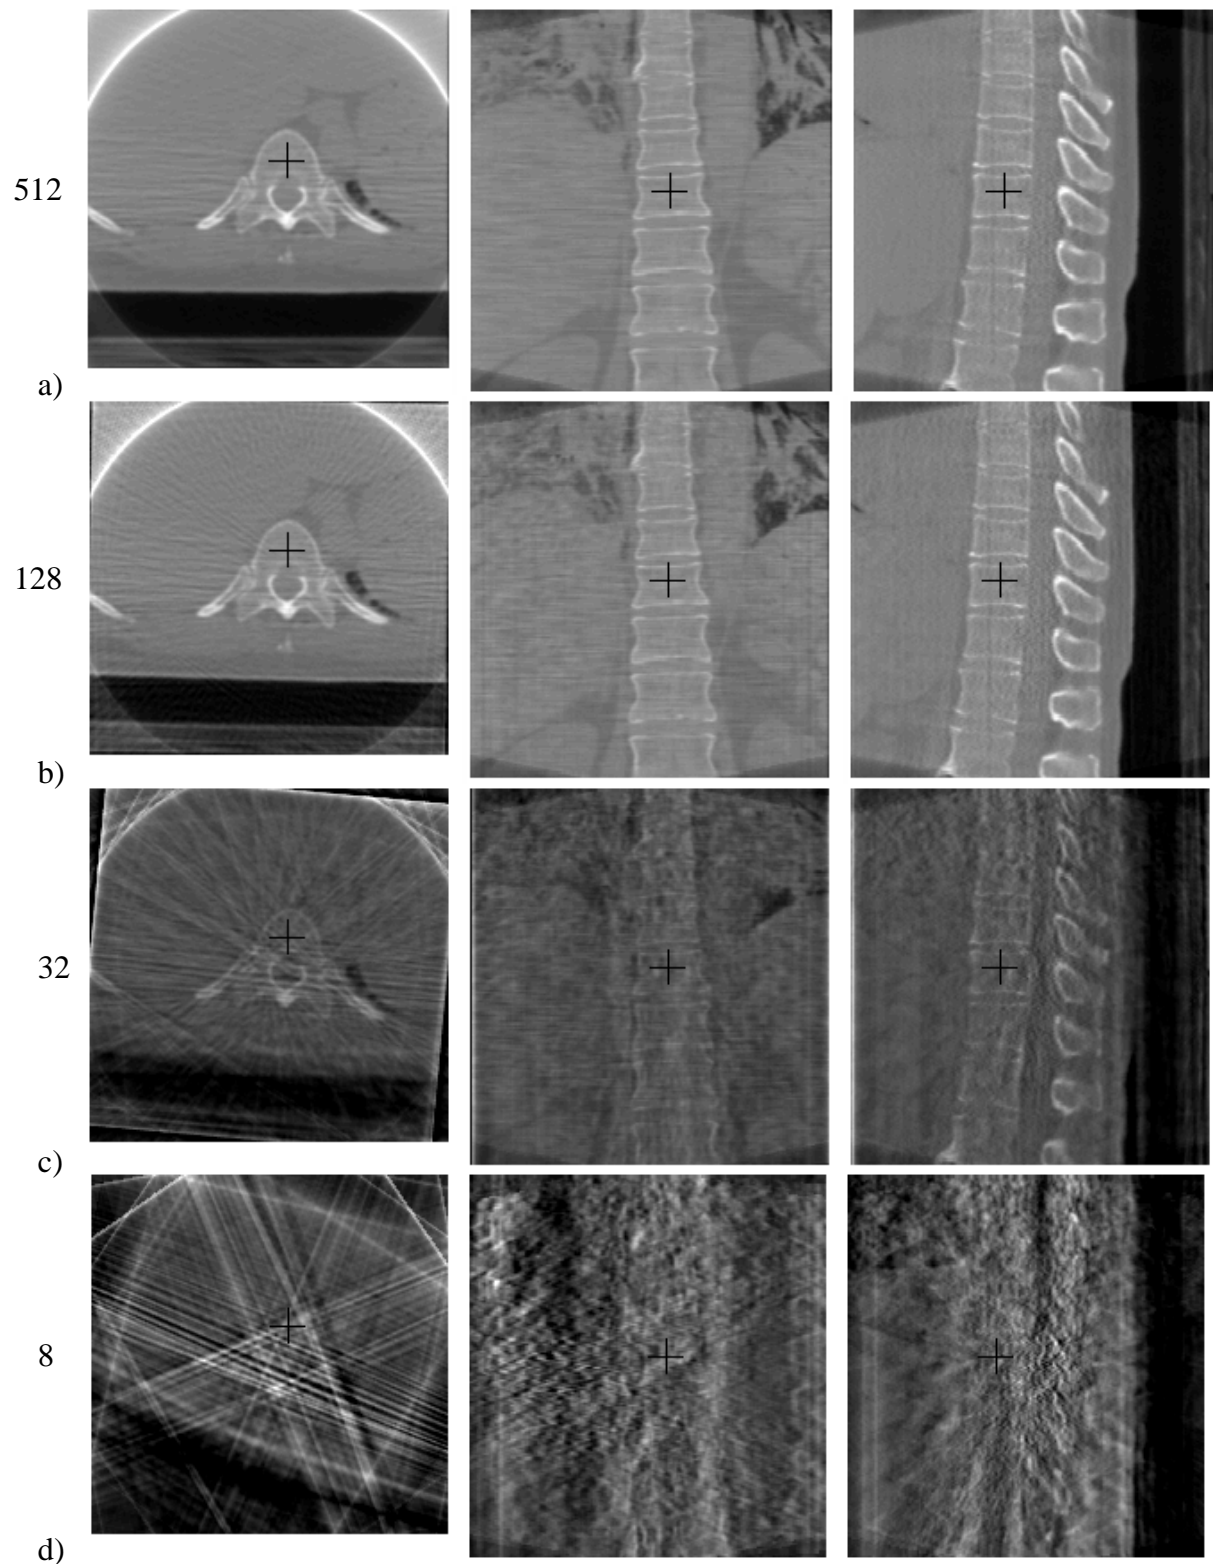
Spine images reconstructed with Feldkamp algorithm using different number of projections. The projections were forward-projected from a regular CT scan (Visible Human Project, VHP). The original image size is 512^2 with 0.9375mm^2 pixel size, slice thickness 1.0mm. The projection image size was 300^2 with 1.43mm^2 pixel size. (Courtesy of Xuan Liu, Brussel University, Belgium) Number of projections used for reconstruction: a) 512, b) 128, c) 32, d) 8
